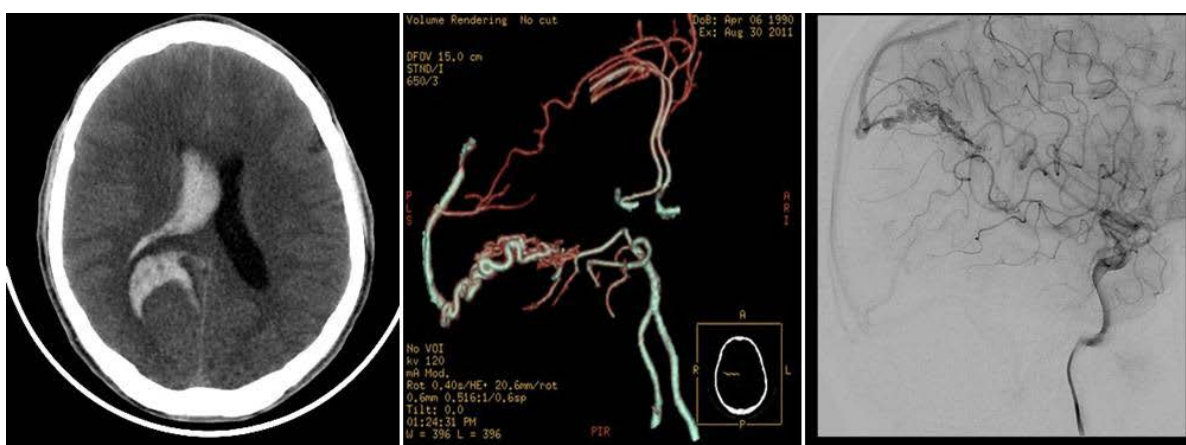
Male patient 21y old with intracerebral hemorrhage and intraventricular hemorrhage, complaining of severe headache. In CTA, enlarged AVM in right posterior cerebral artery and drained in the superior sagittal sinus which conformed by diagnostic catheter based angiography.
